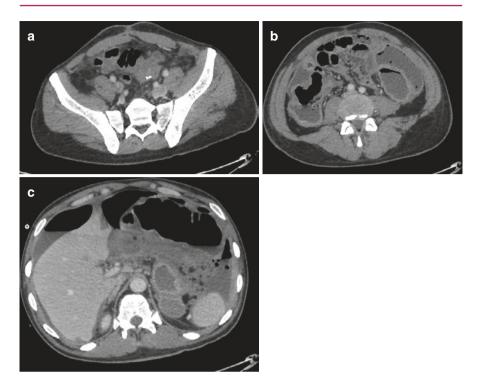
(a–c) CT imaging of a patient (same patient shown in Fig. 10.3) with left colonic obstruction for peritoneal carcinomatosis, after colic perforation and peritonitis. (a) Peritoneal carcinomatosis causing colic obstruction in a patient with previous left colectomy. (b) Resolution of cecum dilatation after colic perforation. (c) Pneumoperitoneum and ascites after colic perforation due to colic obstruction due to peritoneal carcinomatosis
